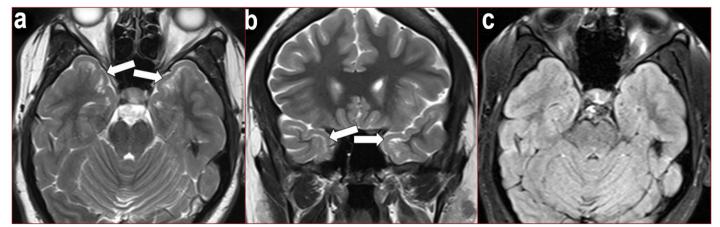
19-years-old girl complains of chronic headache. Hyperintense TZM (arrows) is present in bilateral temporal pole subcortical WM in transverse (a) and coronal T2WI (b). Transvers T2-FLAIR (c) show isointensity according to white matter in same section. (TZM: Terminal zones of myelination, WM: White matter)
